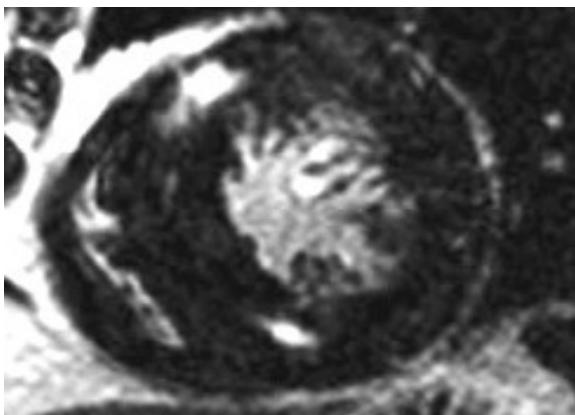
Cardiac MRI short axis view with two bright areas of Gadolinium late enhancement near the left-right ventricular junction
